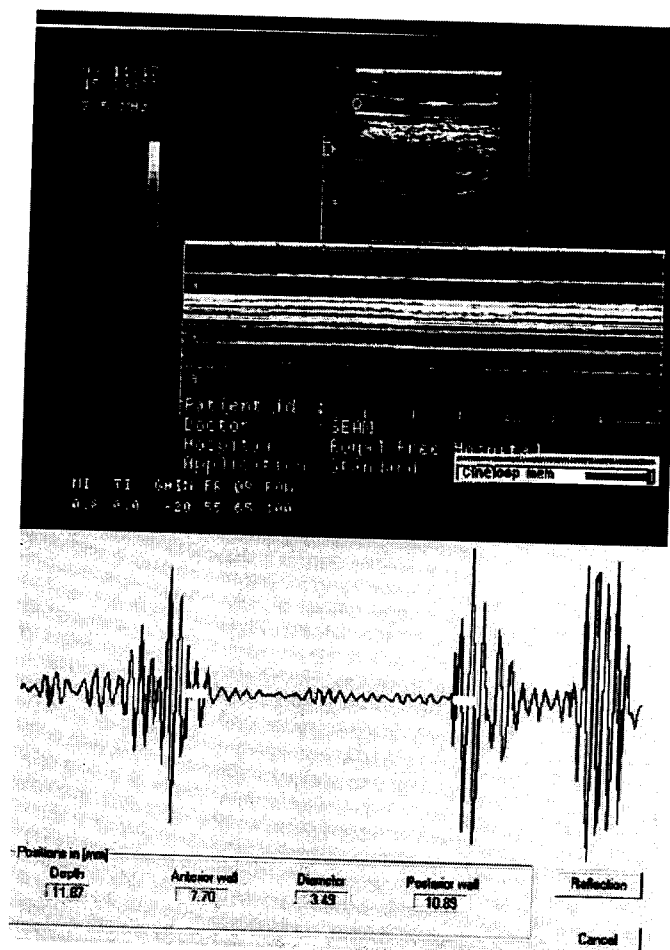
CCA was imaged with specially adapted duplex color Doppler ultrasound system. Vessel wall movement was followed by tracking assigned points of induced radiofrequency signal deemed to be representative of anterior and posterior arterial walls.
